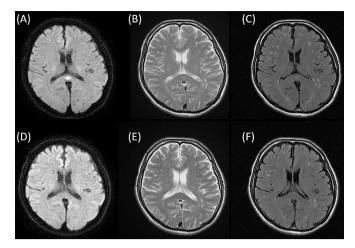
Head MRI on admission and day 21. (A–C) Head MRI on admission day. (A) DWI. Abnormal hyperintensity in the SCC. (B) T2WI. Mild hyperintensity in the SCC. (C) Fluid-attenuated inversion recovery (FLAIR). Mild hyperintensity in the SCC. (D–F) Head MRI on day 21. (D) DWI. Abnormal hyperintensity in the SCC disappeared. (E) T2WI. Hyperintensity in the SCC disappeared. (F) FLAIR. Hyperintensity in the SCC disappeared. SCC, splenium of the corpus callosum; T2WI, T2-weighted imaging.
